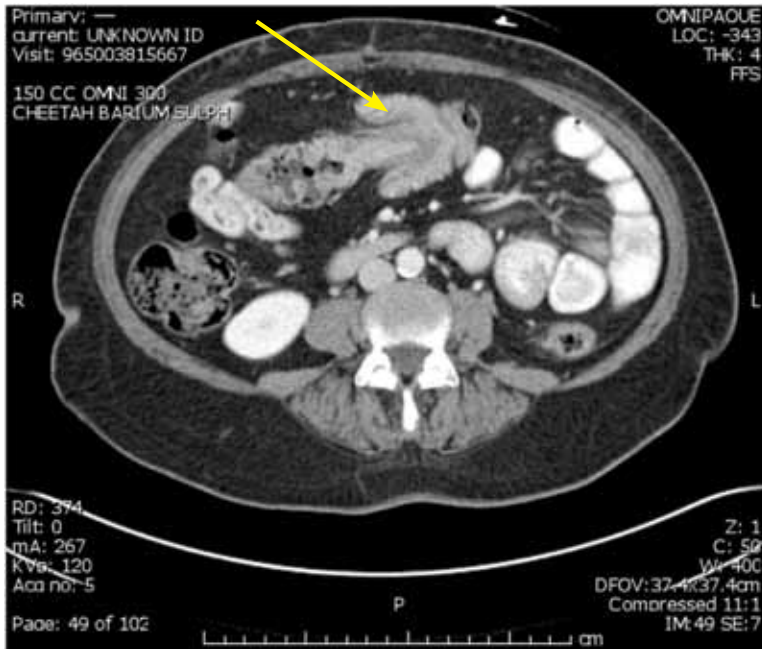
A computed tomography scan of the abdomen showing colonic intussusception (yellow arrow).
